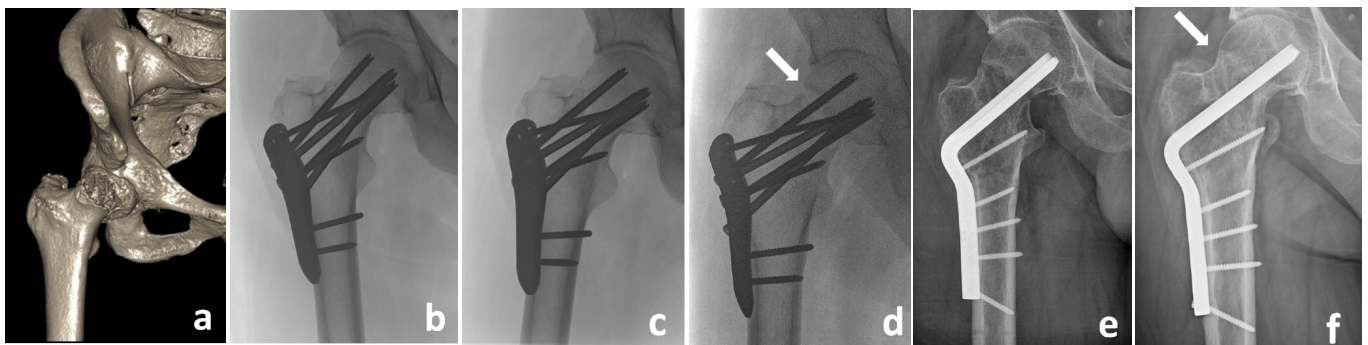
A Fifty-four years old male patient with Pauwels' type III fracture a) 3-D CT reconstruction shows the nature of the fracture b and c) postoperative radiographs d) Postoperative tenth-month control radiograph, arrow shows the persistent fracture line with bone resorption. e) Valgus osteotomy performed as revision surgery f) Complete union was achieved after revision surgery.
